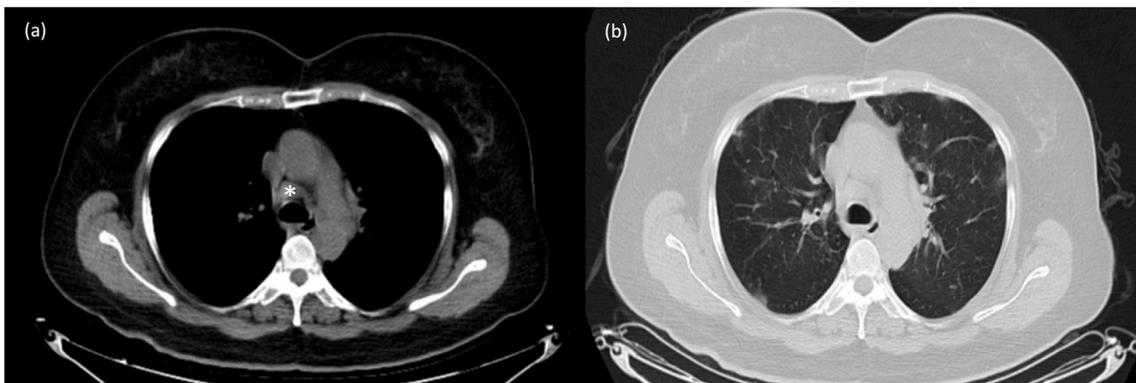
Axial unenhanced chest CT images of a 61 year-old woman with laboratory-confirmed COVID-19 pneumonia. (2a): Mediastinal window showing enlarged lymph node station 4R (2b): Lung window shows peripherally located multiple round ground-glass opacities.
